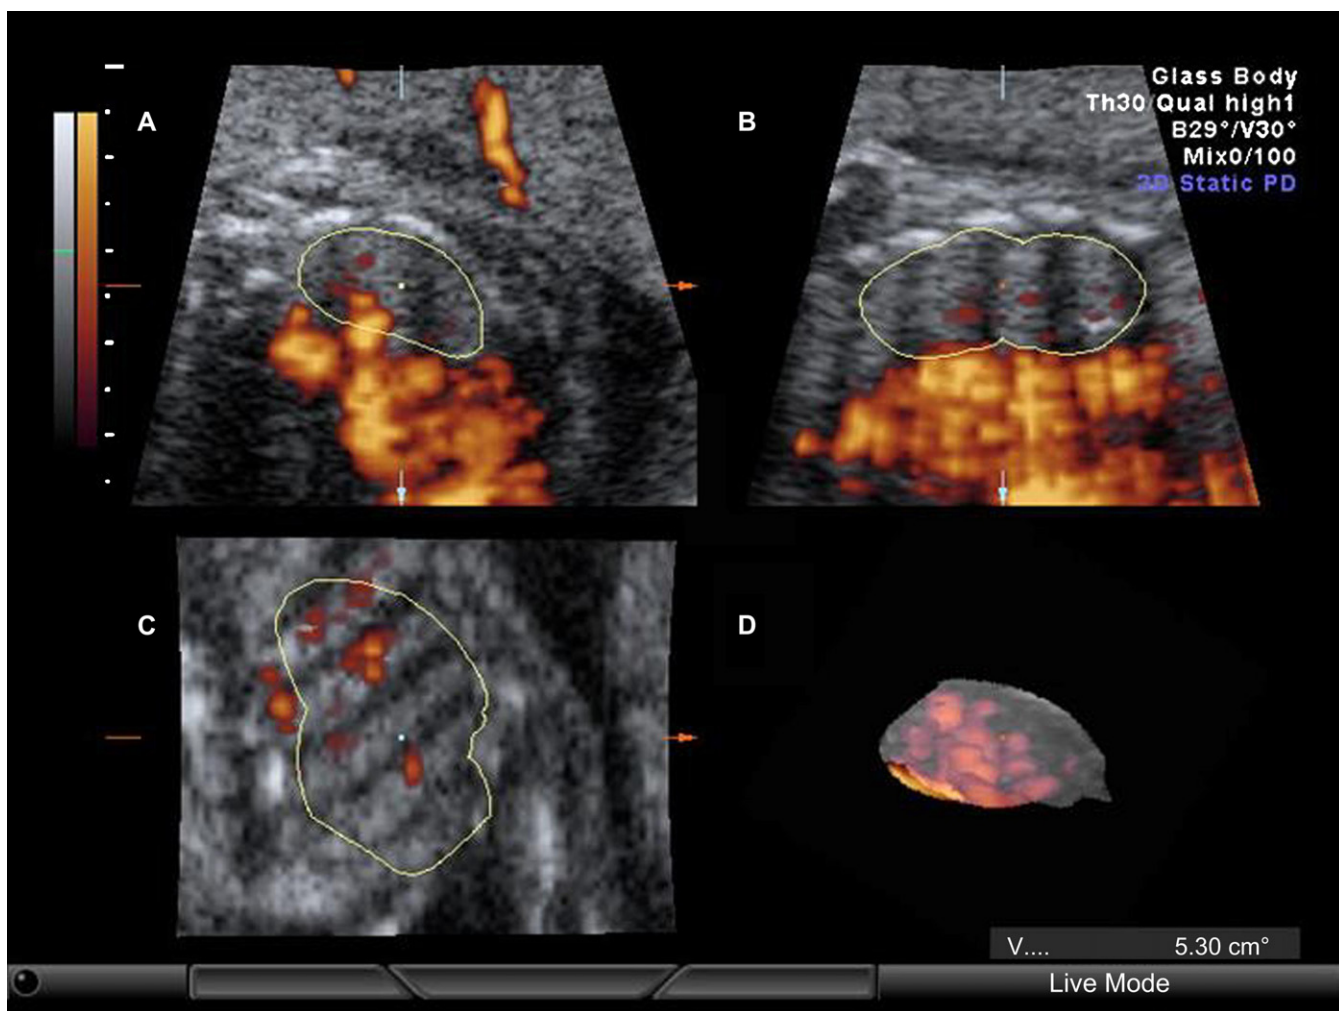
Three-dimensional (3D) power Doppler imaging of the right lung vasculature in a case with left congenital diaphragmatic hernia at 27 weeks of gestation. A, Cross-section; B, sagittal section; C, coronal section; D, 3D rendered mode.
